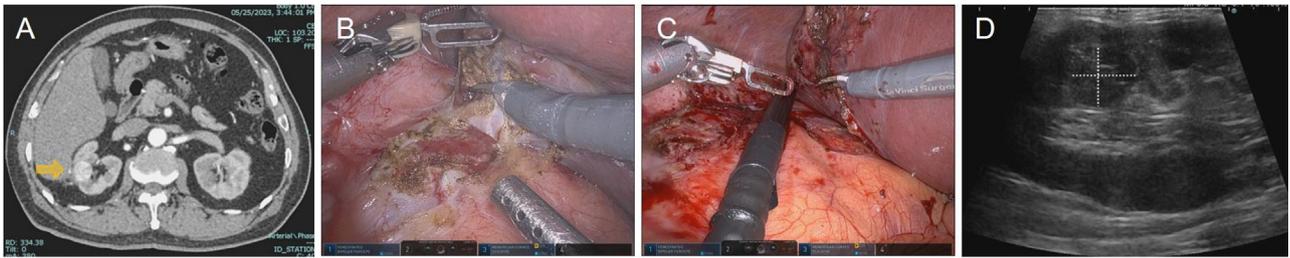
(A) Detailed preoperative imaging of the tumor and abdominal blood vessels is important. Preoperative enhanced computed tomography showed an enhanced nodule of 2.0 cm × 1.9 cm in the right kidney (arrow). (B) The intra-abdominal adhesions were dissected and the Gerota fascia was exposed. (C) The tumor site and abdominal artery were located under laparoscopic ultrasound (LUS). (D) LUS revealed that the tumor was located in the anterior upper pole of the right kidney.
